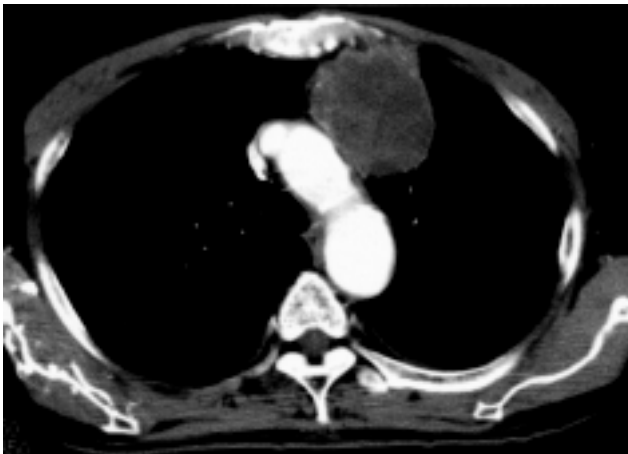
The enhanced computed tomography shows a mass lesion in the upper mediastinum, which contacted the aortic arch and parietal pleura.
